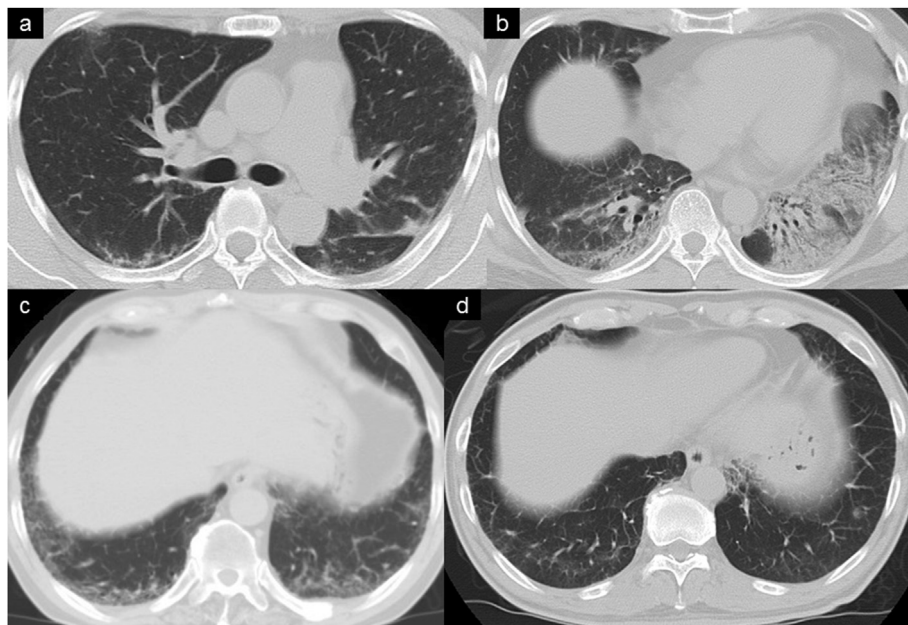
Chest radiograph on admission. Case 1 (a, b): Consolidation was observed in the bilateral dorsal lower lung fields. Case 2 (c): Reticular shadows were observed in the bilateral dorsal lung bases. Case 3 (d): Ground-glass opacities were observed in the bilateral lung bases.
